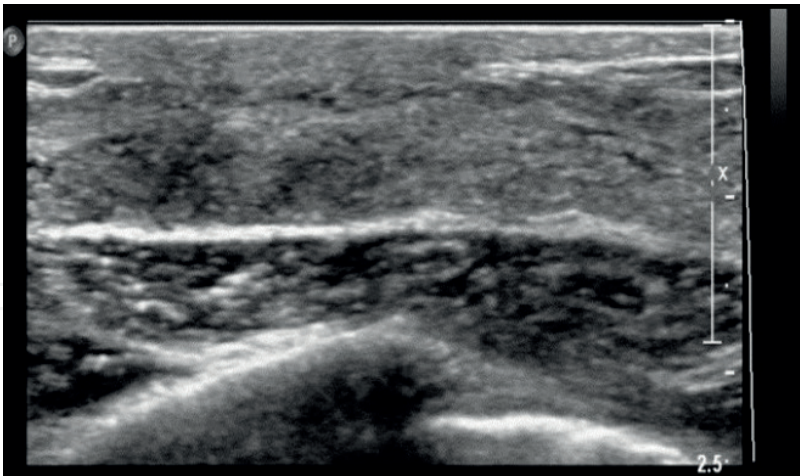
Homogenous background echotexture—fibroglandular. Transverse ultrasound shows a thick zone of homogeneously echogenic fibroglandular tissue present beneath a thin hypoechoic layer of fat lobules.
